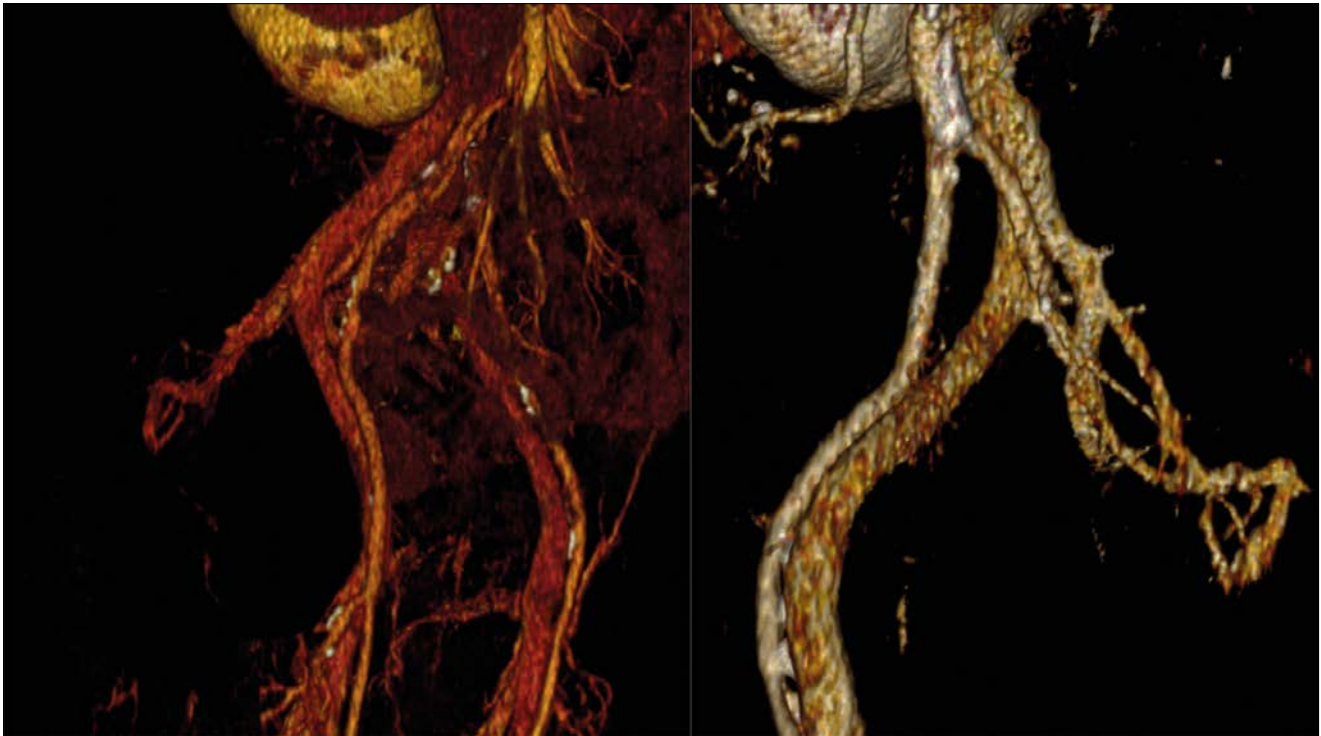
3D CT iliac vein reconstruction.
